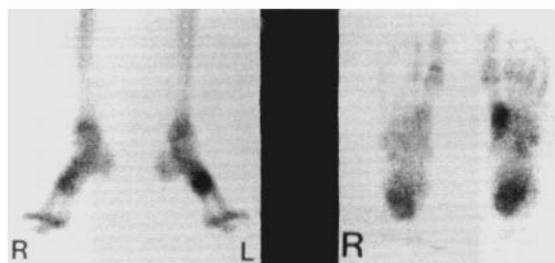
MDP bone scan showing increased uptake at the base of the 1st metatarsal of the left foot, indicating early bony damage despite normal X-ray.
